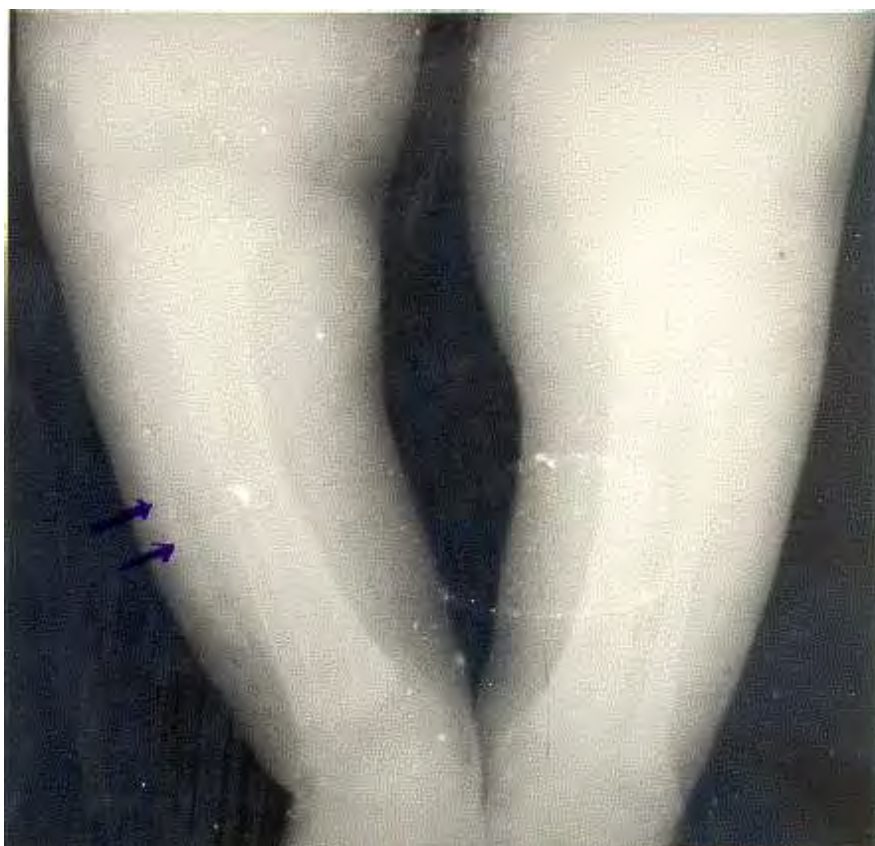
Roentgenogram of the lower extremities showing diffuse subcutaneous calcifications (arrow).
